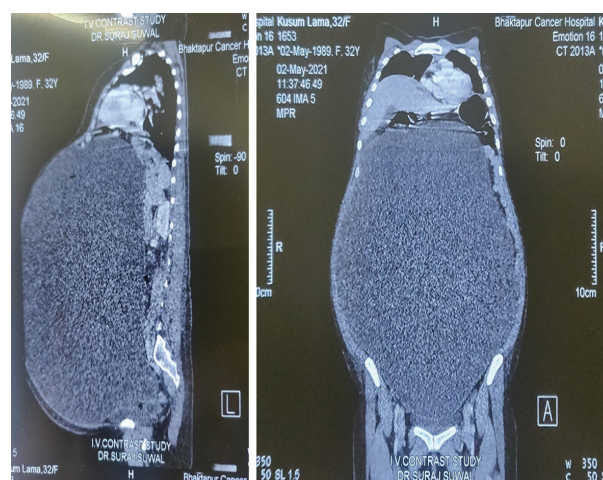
Image of abdomen and pelvic contrast enhanced computed tomography showing large size of cyst.
